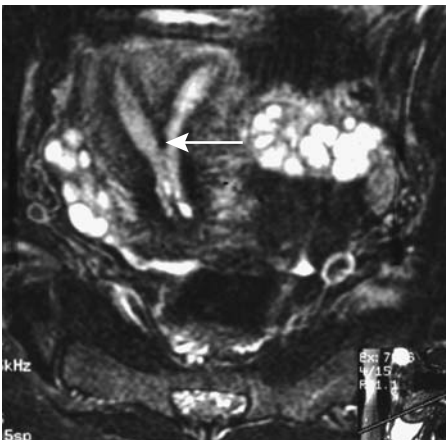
Septate uterus (arrow) identified on T2-weighted transverse oblique MR image. (Source: Burgener FA, Meyers SP, Tan RK, Zaunbauer W. *Differential Diagnosis in Magnetic Resonance Imaging*. Stuttgart: Thieme, 2002, with permission.)
